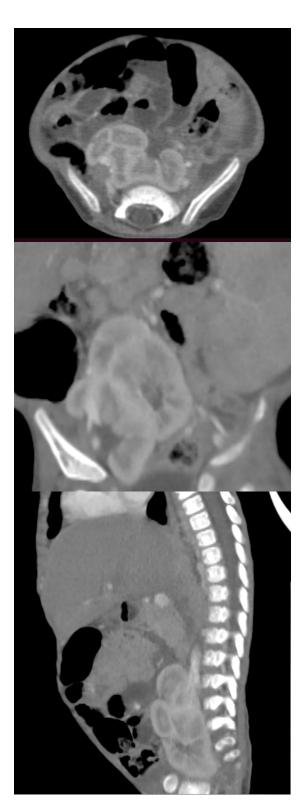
Thoraco-abdominal computed tomography image
